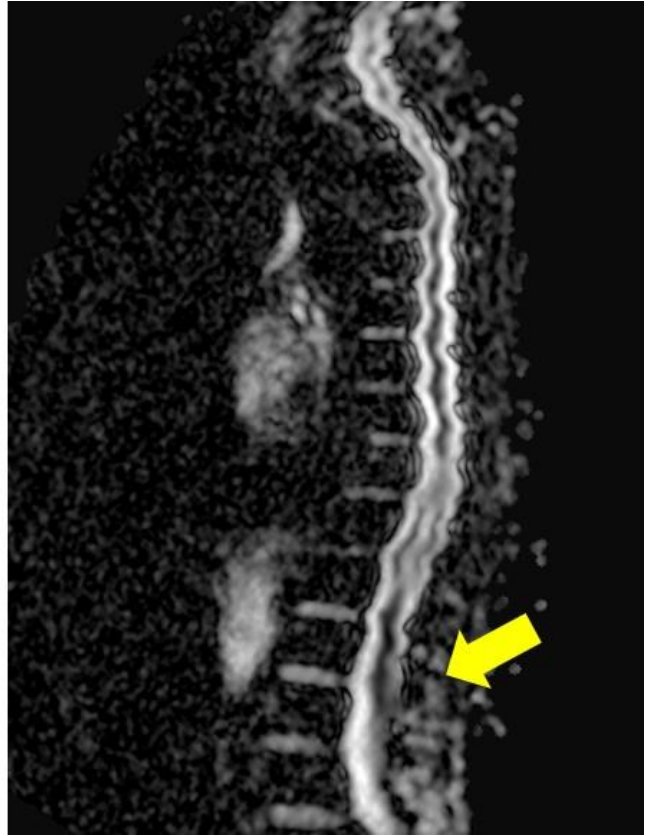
Images of spinal cord diffusion MRI of the patient, showing diffusion restriction at the T11-L1 level of the spinal cord.
